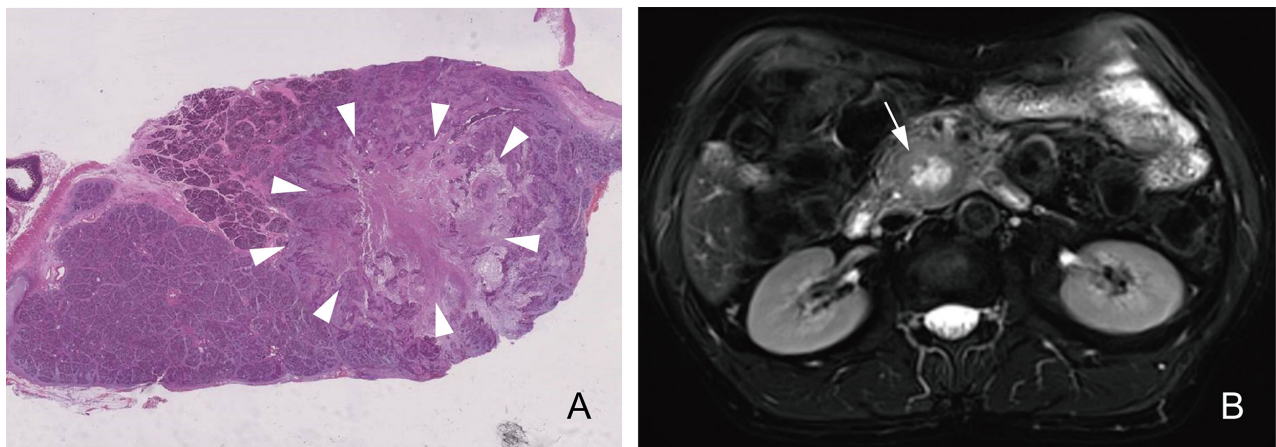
Cystic degeneration caused by pancreatic adenocarcinoma. (A) The tumor with central necrosis (arrowheads) (HE×1). (B) Axial T2-weighted magnetic resonance image shows a round, ill-defined, mild, hypointense mass with central hyperintense necrosis (arrow).
